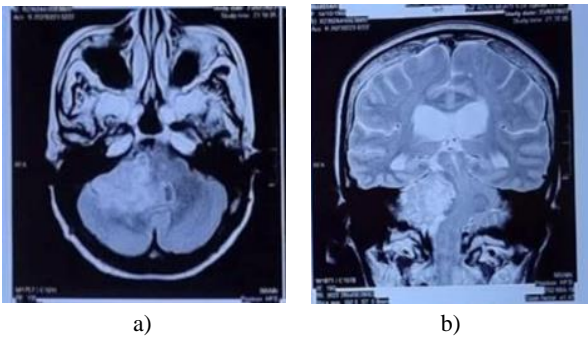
Head MRI Contrast
